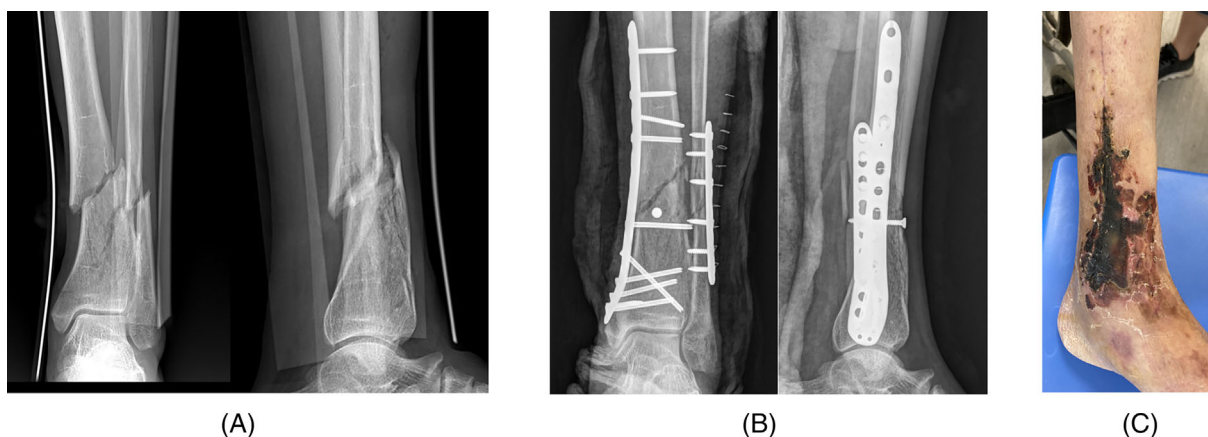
A man with a tibia fracture underwent open reduction and internal fixation, and skin necrosis appeared after the operation. (A) X-ray before operation. (B) X-ray after the operation. (C) Skin necrosis
